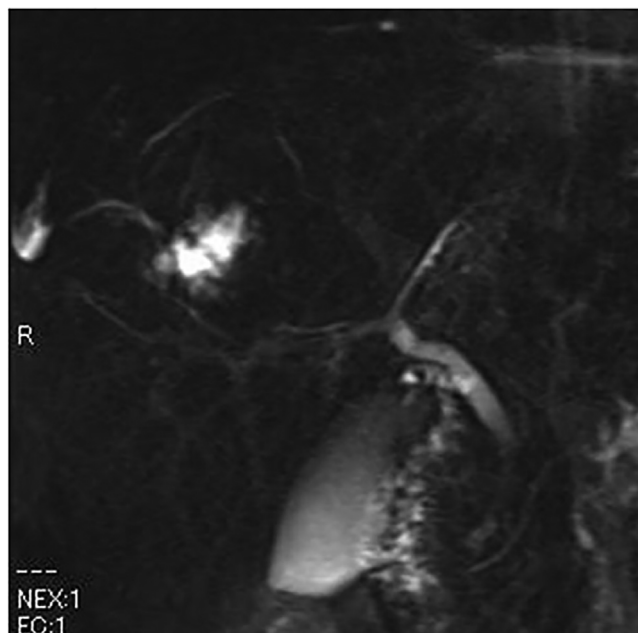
MRI images at admission. Peripheral dilation of the intrahepatic bile duct of the 8th branch can be seen, suggesting bile duct invasion.
